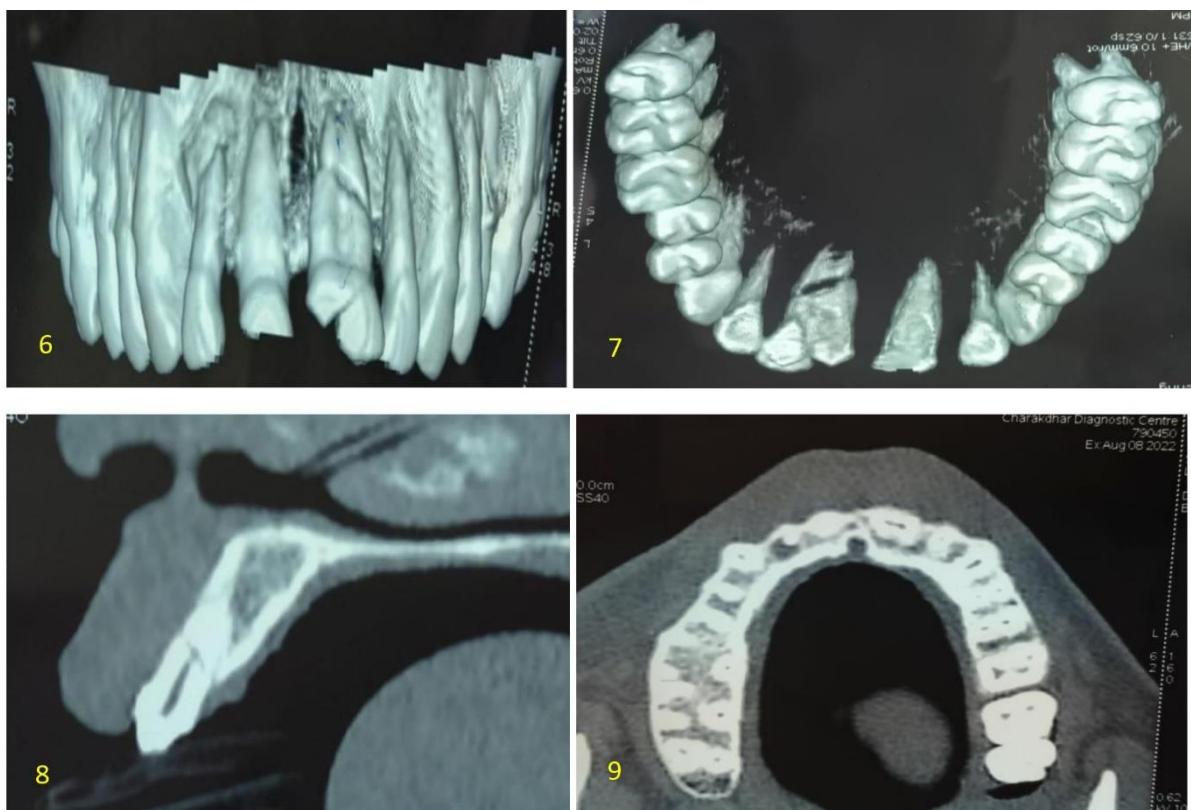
CT images of fractured geminated central incisor
